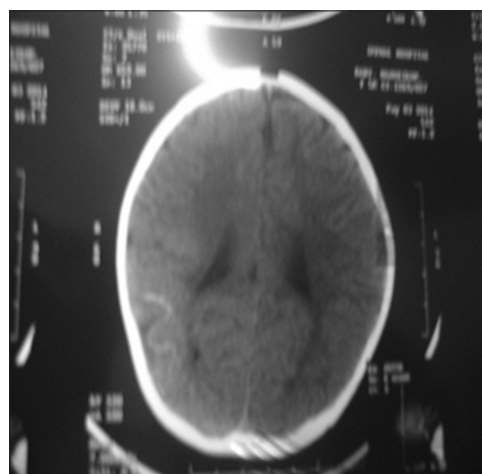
Computed tomography scan of brain showing leptomeningeal calcification in right parietal lobe
